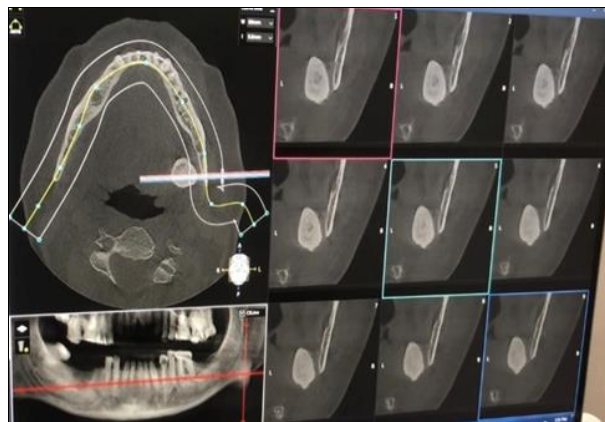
Pre-operative CT view
